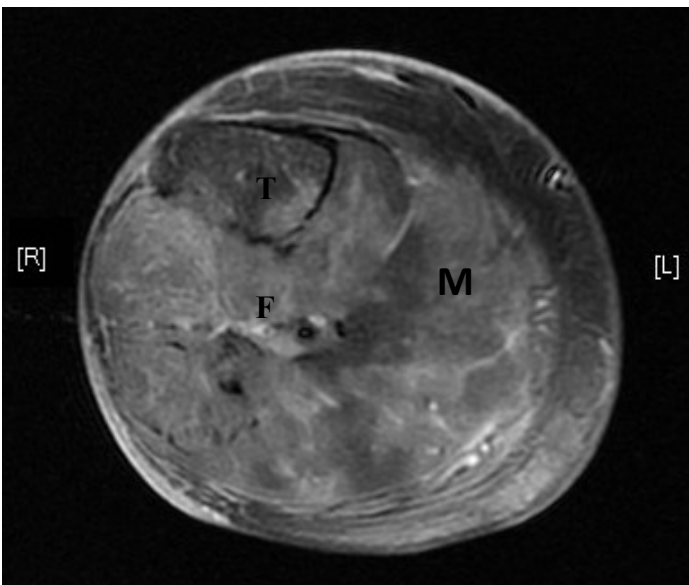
MRI of the right leg showing infiltration of the muscles by a heterogeneous mass (M); Tibia (T); Fibula (F).
